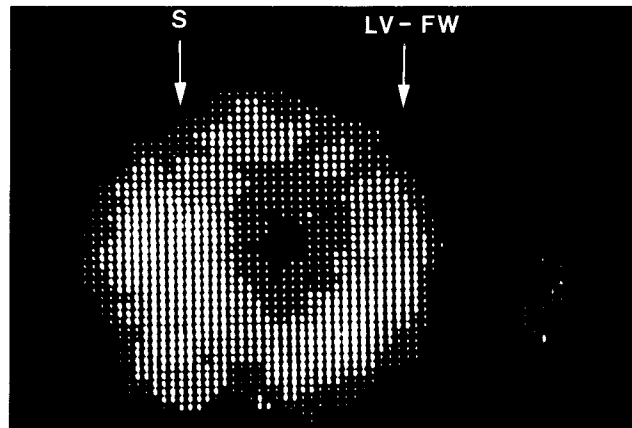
Thallium-201 scintigram (45° LAO projection) of a 33 year-old patient with hypertrophic cardiomyopathy. The diagnosis is confirmed by the finding of an S/LV ratio greater than 1.3. (S = septum, LV-FW = left ventricular free wall.)
